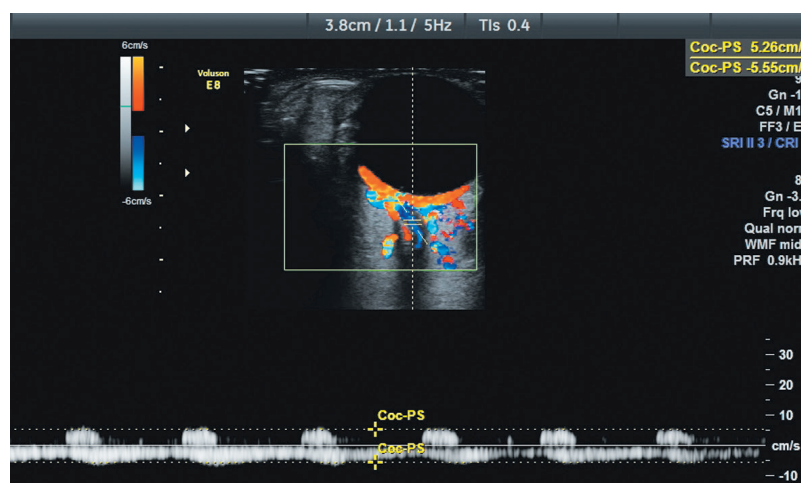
Doppler image of blood flow in the central retinal artery and central retinal vein at intraocular pressure of 60 mmHg. Peak systolic velocity is decreased (PSV 5.26 cm/s); the diastolic component is not observed (EDV 0).
